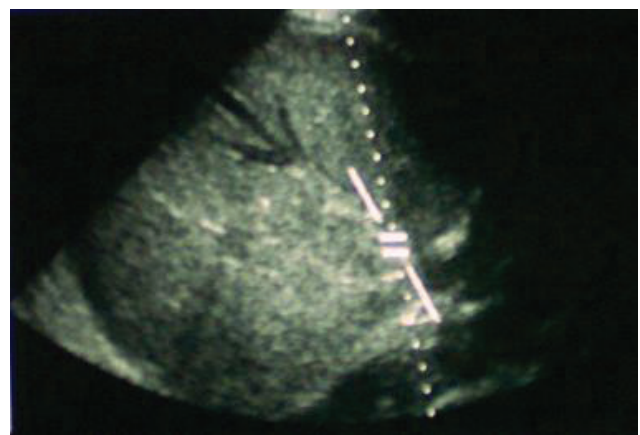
Sonography showing hepatic vein thrombus.
